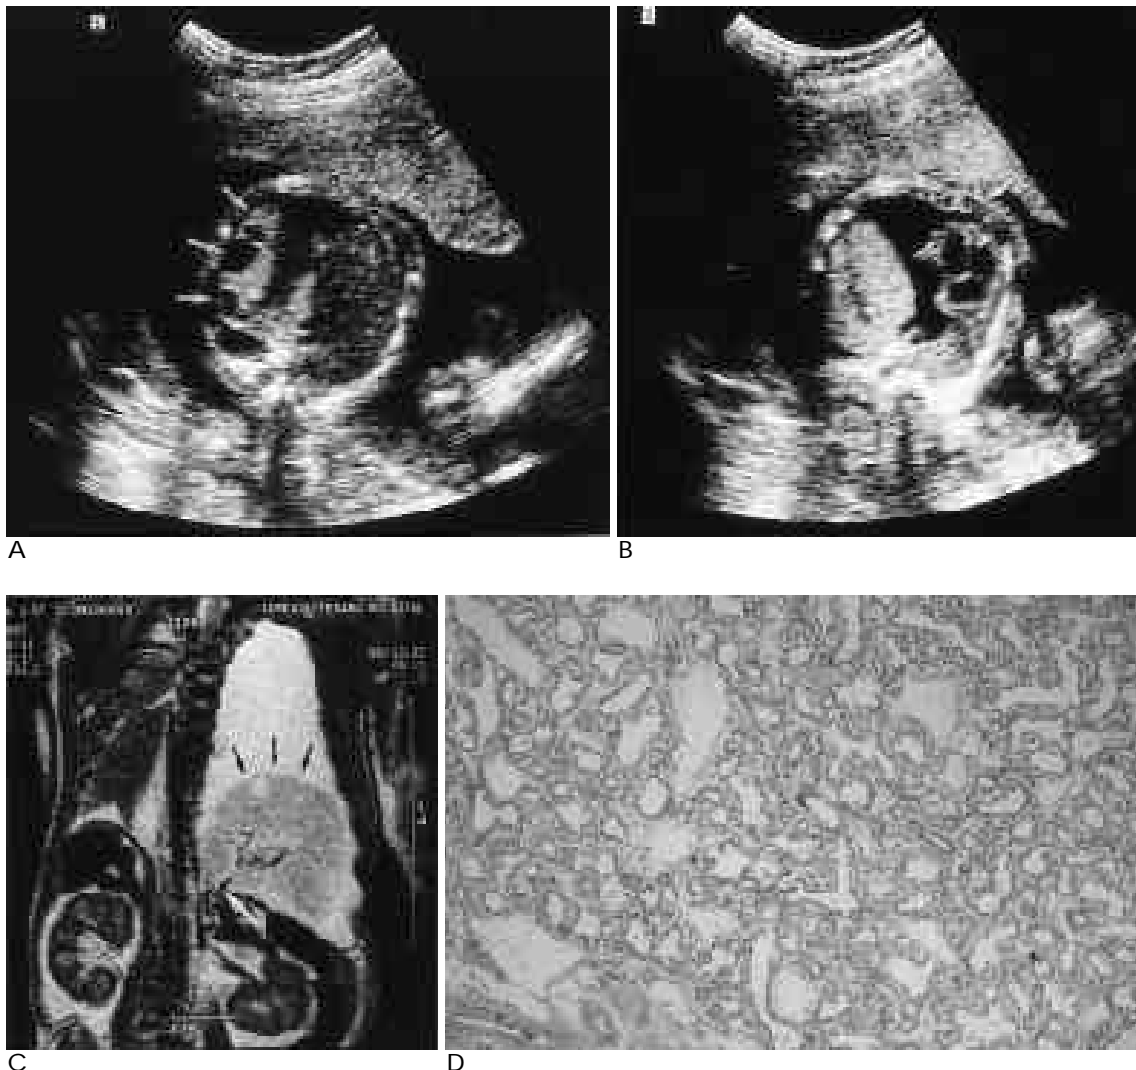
A. Transverse sonogram of fetal chest shows a huge echogenic mass with multiple variable sized cyst (white arrows) that occupied the left lower chest. Left lung parenchyma is markedly collapsed and large amount pleural effusion is visible.
